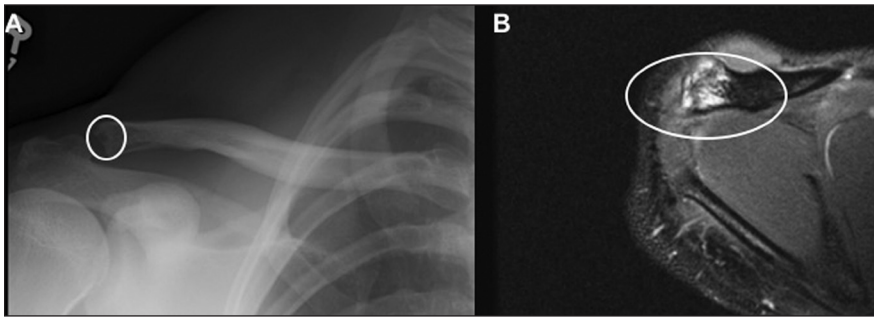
Preoperative anteroposterior radiograph (A) and T2-weighted axial magnetic resonance image (B) showing lytic changes in the distal clavicle (white circle) in a male weight lifter with distal clavicle osteolysis.
